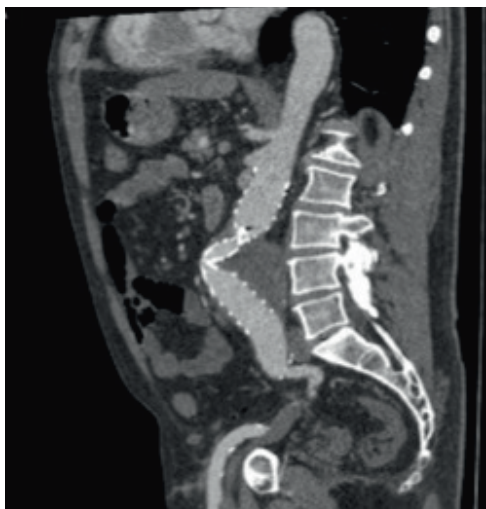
Computed tomography scan before re-intervention, showing migration of the iliac limb at the distal landing site with loss of attachment and severe kinking of the graft.
